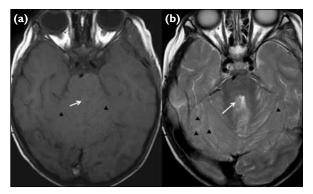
(a) TI-weighted (TIW) and (b) T2-weighted (T2W) magnetic resonance axial images showing a tiny TIW and T2W isointense nodule (arrow) over the lateral wall of the fourth ventricle. There are also TIW isointense and T2W hyperintense nodularities along the cerebellar foliae (arrowheads)
